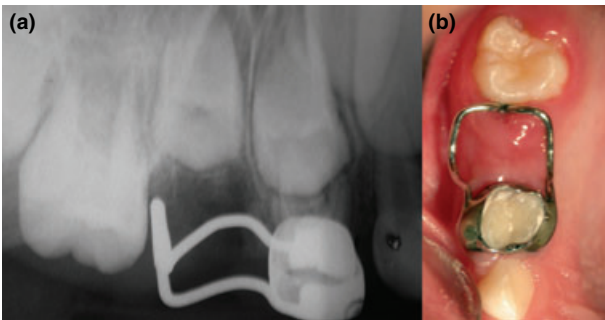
(a) Periapical radiograph. Confirmation of the correct position of the distal shoe; (b) Intra-oral view of the distal shoe.
